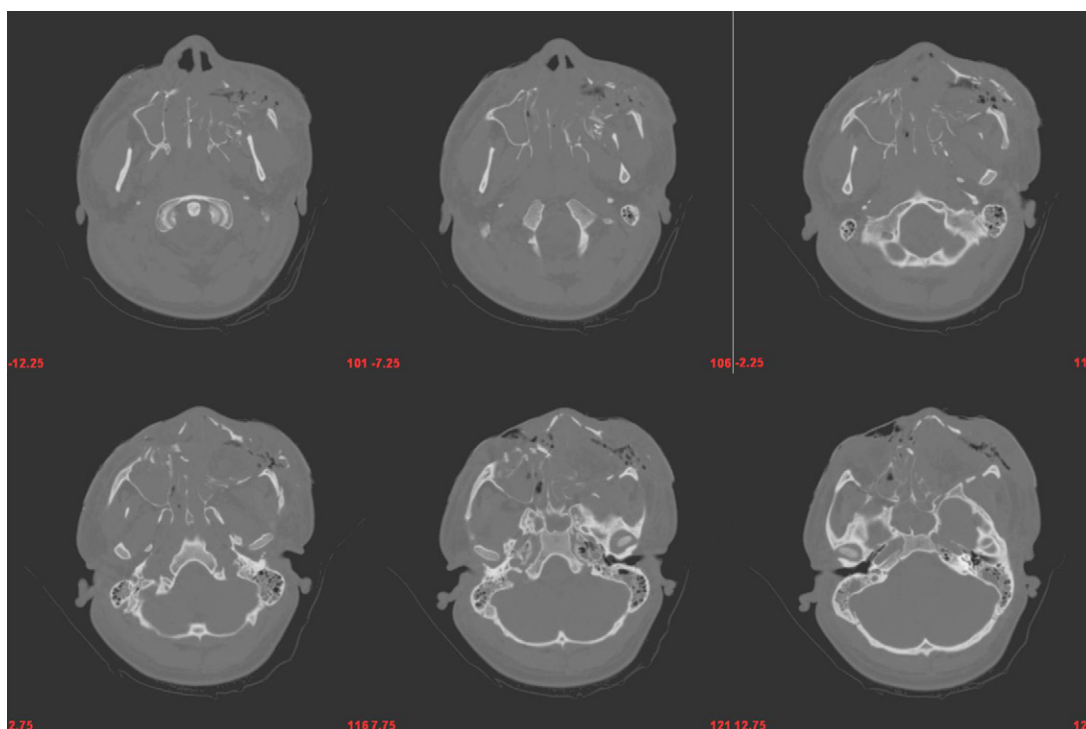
CT series of a midface injury.
